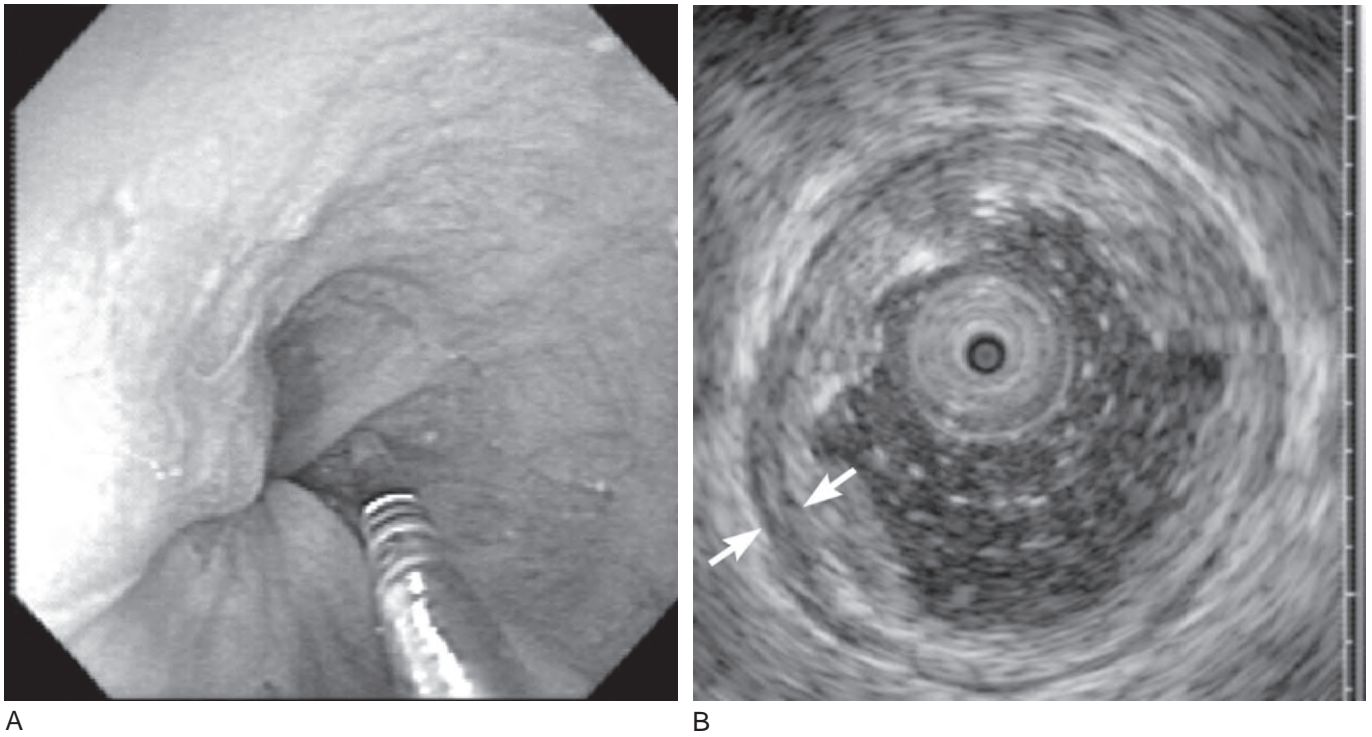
A, High-frequency (12 to 30 MHz) miniprobe passed through the operating channel of a standard endoscope. B, Miniprobe ultrasound image of a normal esophagus. The probe is not centered in the undistended esophageal lumen. The mucosa and submucosa are the inner hyperechoic layer. The muscularis propria (*arrows*) is the inner hypoechoic layer.
